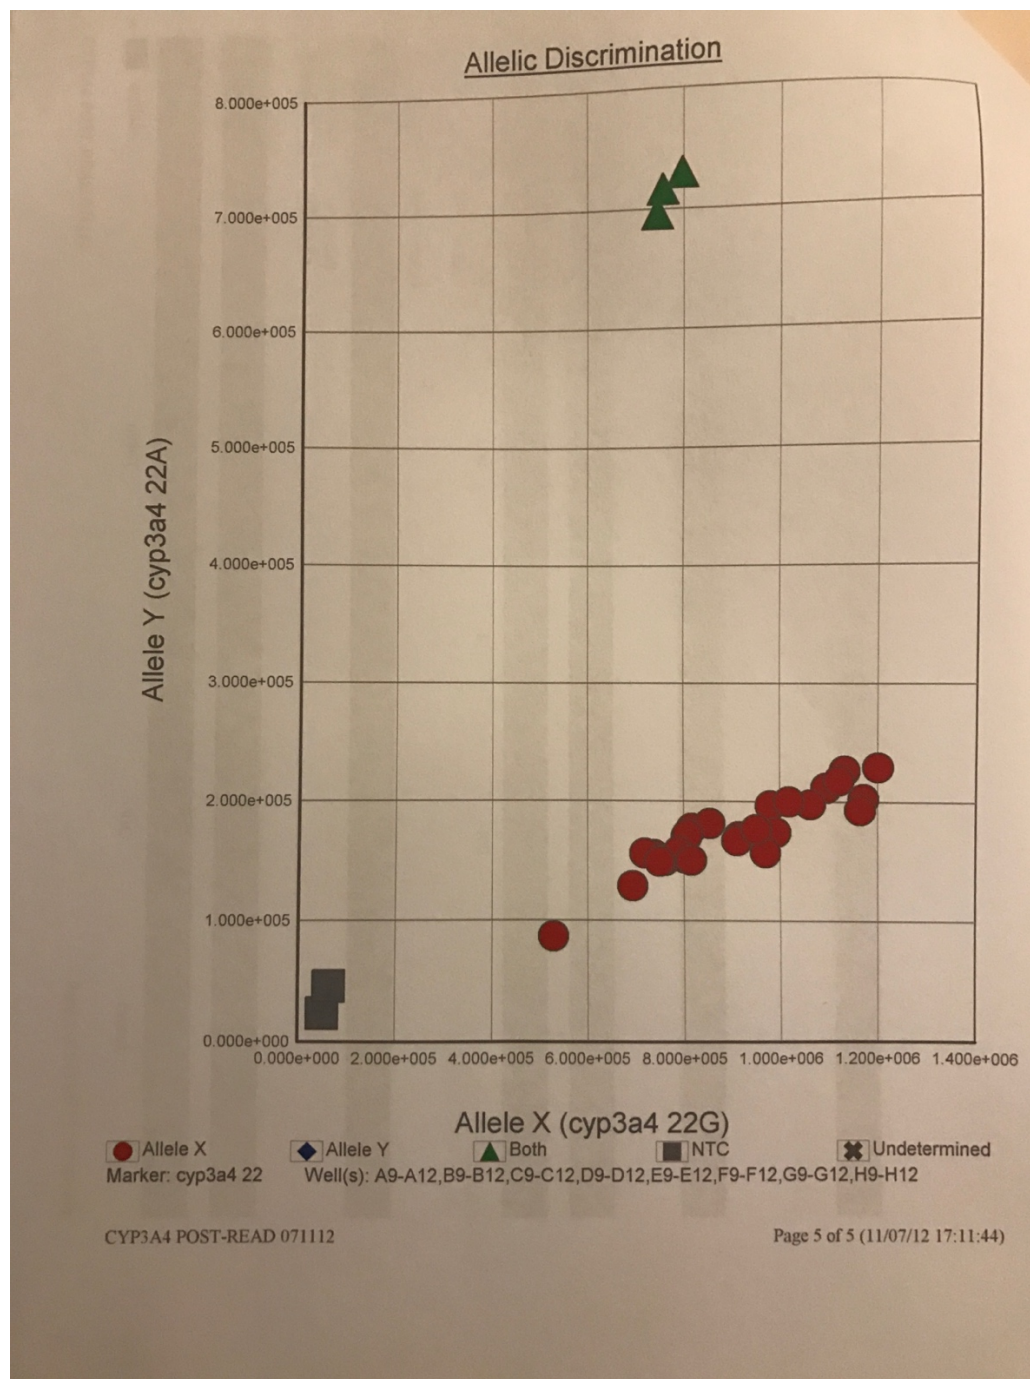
RT - PCR output for CYP3A4*22 Alleles. The CC genotype represented by the red dots and the CT allele represented by the green triangles, note there are no TT genotypes in this run, a reflection of the rarity of this genotype. Grey squares are NTCs.
